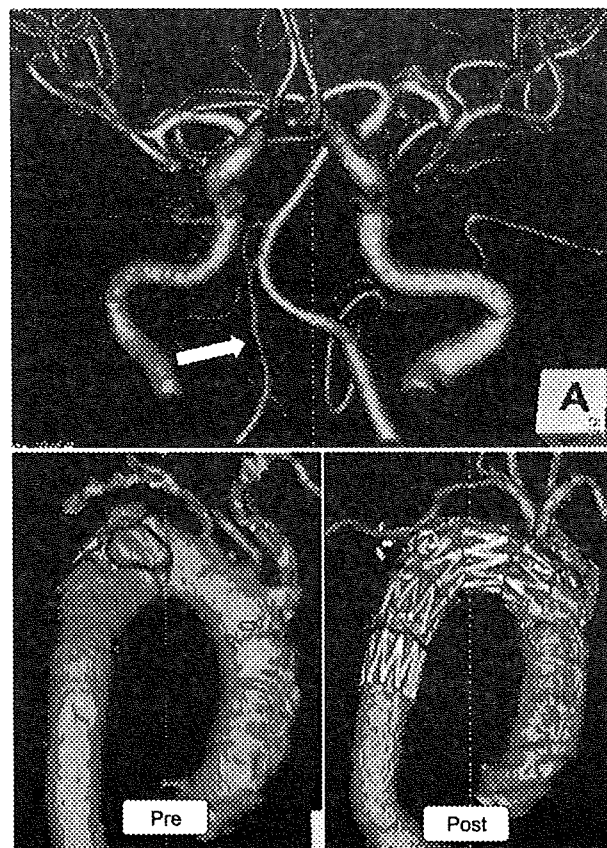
Computed tomographic angiography (CTA) images. CTA of the vertebro-basilar artery revealed hypoplastic right vertebral artery (white arrow) (upper). A fenestrated stent graft well preserved antegrade blood flow into the left subclavian artery as well as the left common carotid artery (lower).
